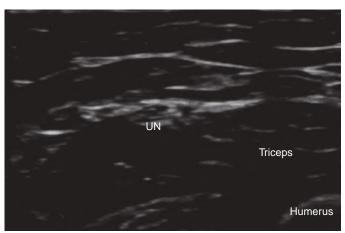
Ultrasound image of ulnar nerve (UN) at the level of the elbow.
